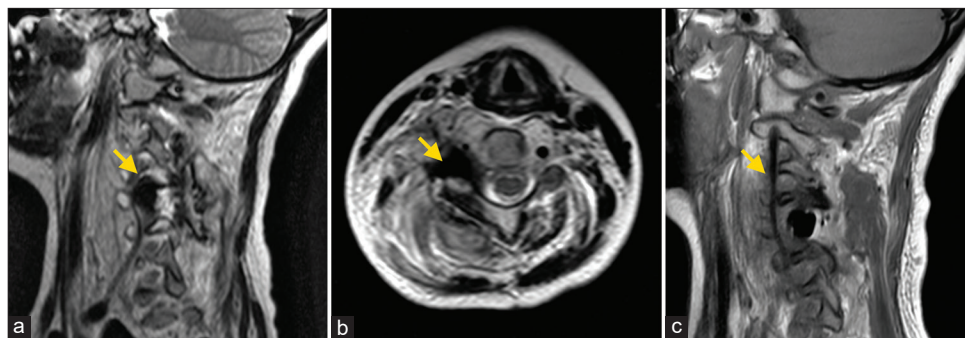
(a) Post-operative sagittal T2-weighted MRI depicting a hypointense mass lesion (arrow). (b) Axial T2-weighted MRI scan showing compression of the right C5 nerve root trace by the hypointense mass (arrow). (c) Post-operative sagittal T1-weighted MRI showing vertebral artery (arrow) trace.
